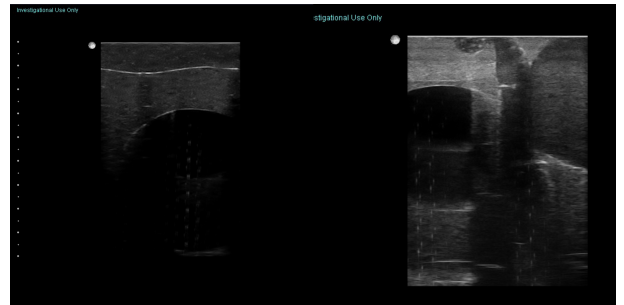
Ultrasound image for Abdominal Probe(left) and Trus Probe
